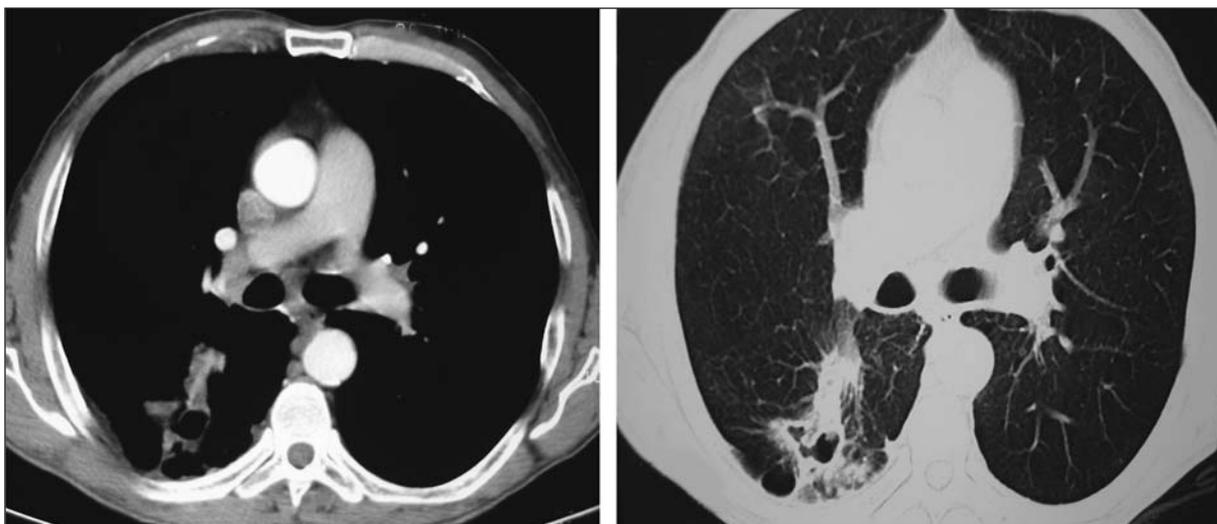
Thorax CT revealed a cavitory pulmonary mass localized to the superior segment of right lower lobe.
